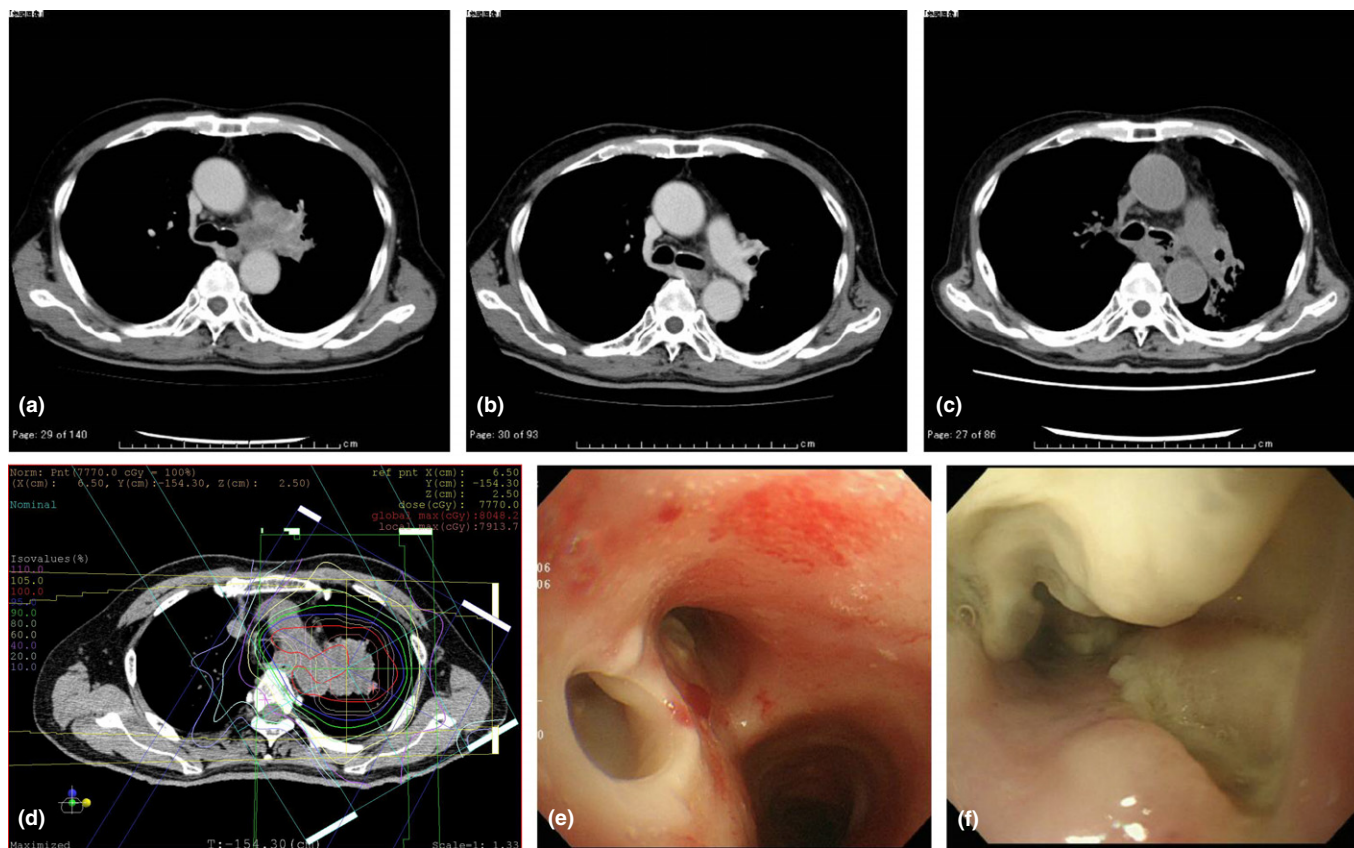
Grade 3 esophageal fistula occurring in a patient 9 months after the initiation of PBT. Upper left: (a) CT image at pre-treatment. Upper middle: (b) CT image at 2 months after the initiation of PBT. Upper right: (c) CT image at 9 months after the initiation of PBT. Lower left: (d) PBT dose distribution. Lower middle: (e) Upper GI endoscopy at 9 months after the initiation of PBT. Lower right: (f) Bronchial endoscopy at 9 months after the initiation of PBT. CT, computed tomography; GI, gastrointestinal; PBT, proton beam therapy.
